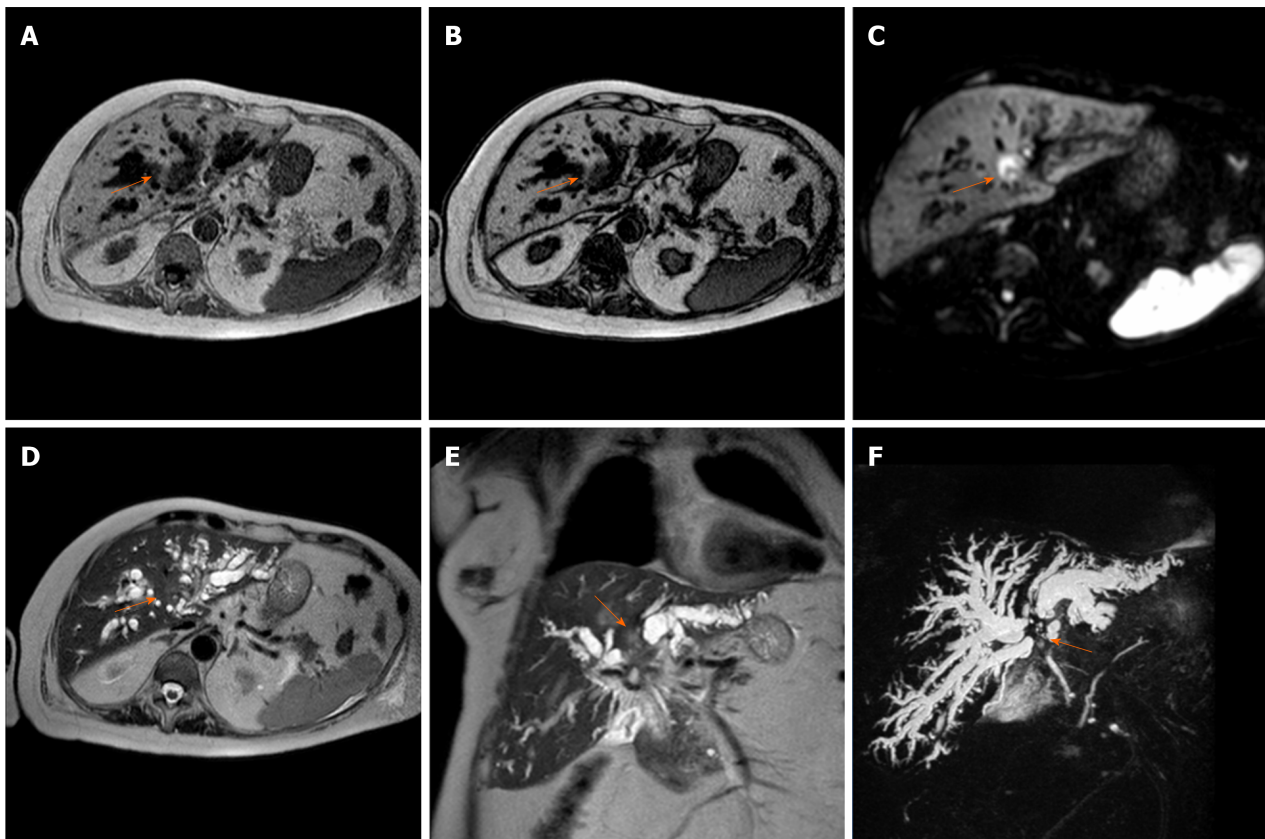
Perihilar cholangiocarcinoma. A case of pCCA (orange arrow), arising at the junction with the involvement also of in the right and left hepatic duct, in an 86-year-old female. The magnetic resonance cholangiopancreatography is reported. The lesion is a hypointense mass in T1-weighted images. A and B: Hyperintense in the higher b-value of diffusion-weighted images; C: Mild hyperintense on T2-weighted images; D and E: Finally the use of the 3D respiratory-triggered heavily T2-weighted FSE sequences; and F: Maximum intensity projection reconstruction is useful to detect the strictures at the junction of the biliary tree.
